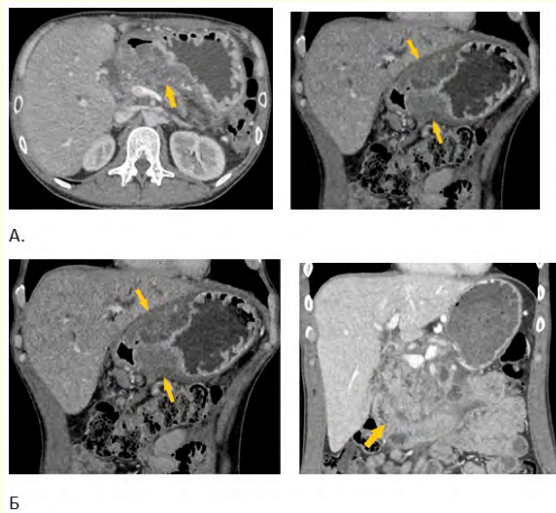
Computed tomography of the abdominal organs in patients with chronic pancreatitis and hepatitis due to MM edema. A. thickening of the stomach wall; B. Thickening of the wall of the duodenum.
